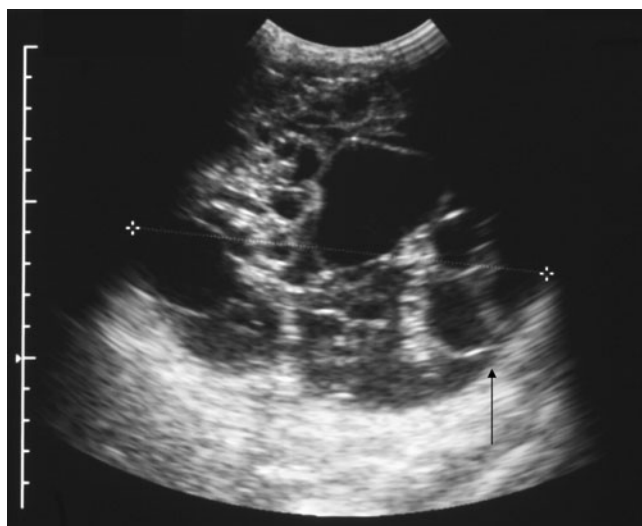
A sagittal ultrasound image of the left kidney shows a renal mass with multiple anechoic areas and posterior acoustic enhancement. The “beak sign” (arrow) suggests the renal origin of the mass
